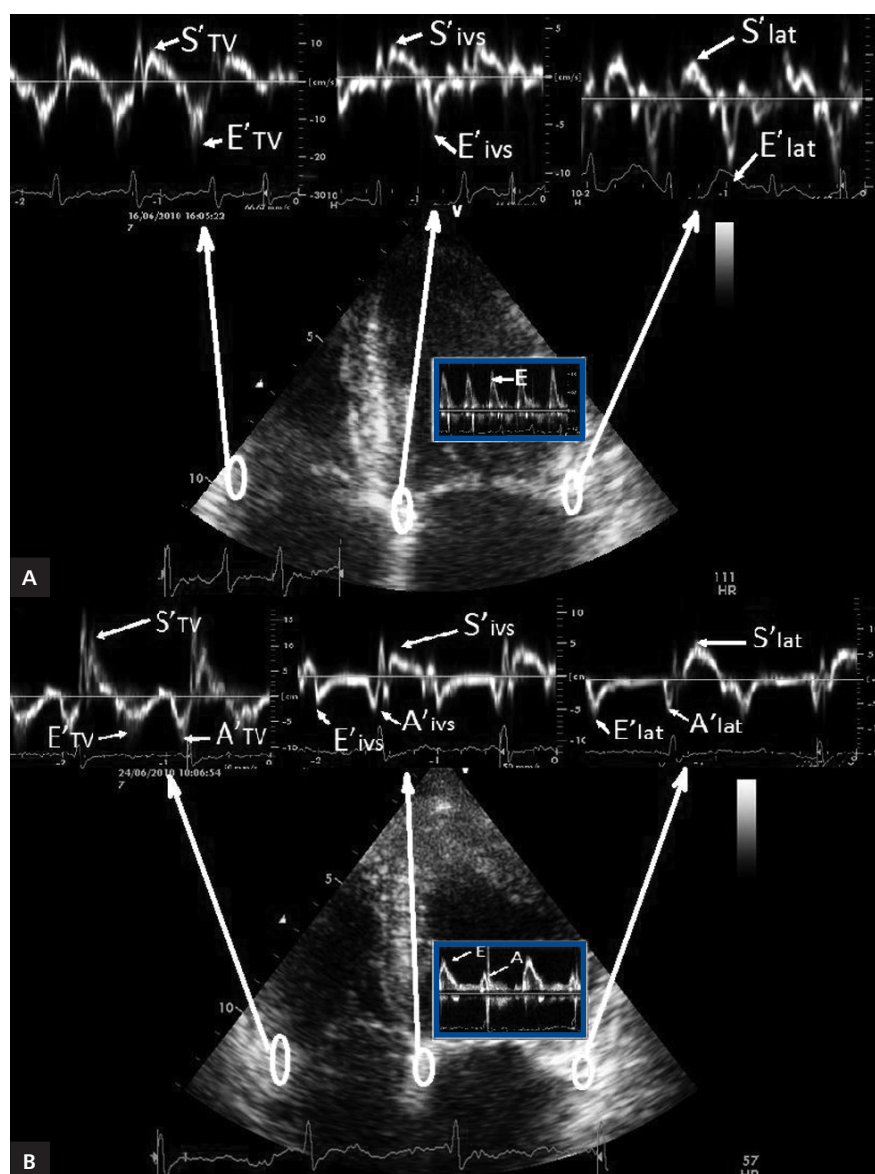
A. Transthoracic tissue Doppler echocardiography (TDE); apical four-chamber projection: tissue Doppler spectra (long arrows) obtained from three sample gate locations (ellipsoids). Measured parameters: early diastolic (E') and systolic (S') tissue Doppler annular velocities (short arrows), early-diastolic velocity (E) on mitral inflow spectrum determined by means of conventional echocardiography (blue frame); B. Transthoracic TDE following the sinus rhythm restoration: A' wave (A) visible in the spectrum of mitral inflow (blue frame), along with A' wave resulting from atrial systole on tissue echocardiography
